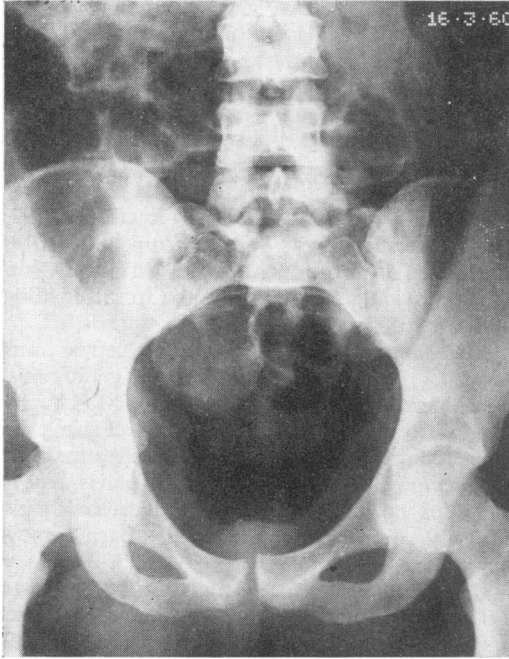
Radiograph showing bilateral enlargement of the ovaries.
